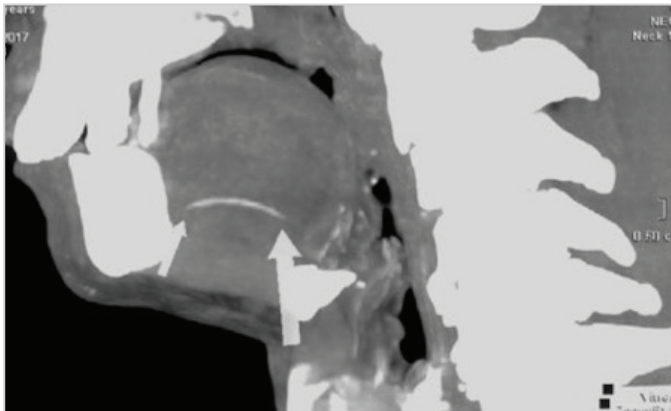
Sagittal computed tomography scan of the neck showing the anterior (small arrow) and posterior ends (large arrow) of the fishbone embedded in the genioglossus muscle
